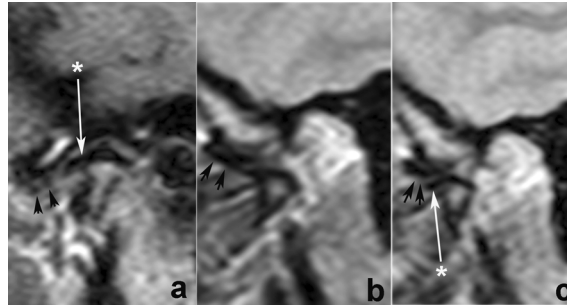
Follow-up examination of the right temporomandibular joint by magnetic resonance imaging in the position of habitual maximum intercuspitation (a), forced anterior position (b) and open mouth position (c). Note: non-reduced and deformed anterior displaced disc (short arrow) and the osteophyte formation on the anterior edge of the condyle (long arrow).
